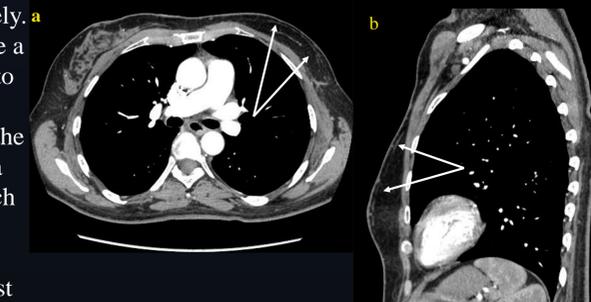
Axial (a) and Sagittal (b) CTA for pulmonary embolism demonstrates left TRAM flap and thin band of de-epithelialized skin (arrows).
